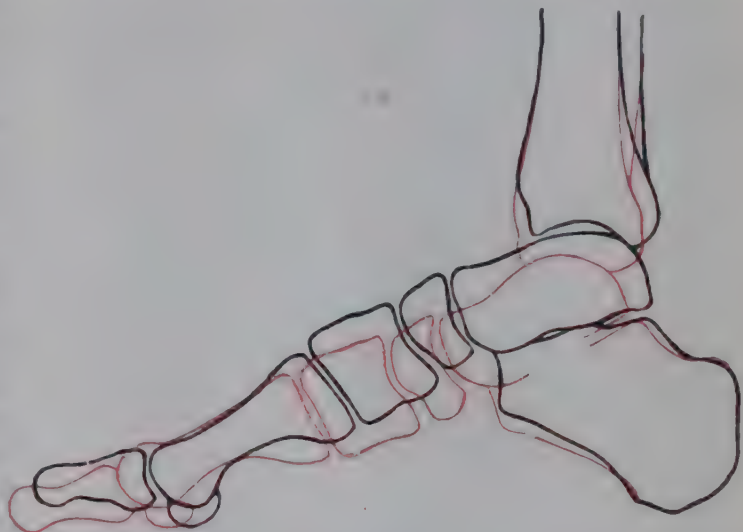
TRACINGS OF RADIOGRAPHS (Pl. XLVI, p. 547, Figs. 2 and 3), superimposed to show the position of the Longitudinal Arch of the Foot during Relaxation (red), and Contraction (black) of the Muscles. (See also Fig. 472, footprints 2 and 3.)
